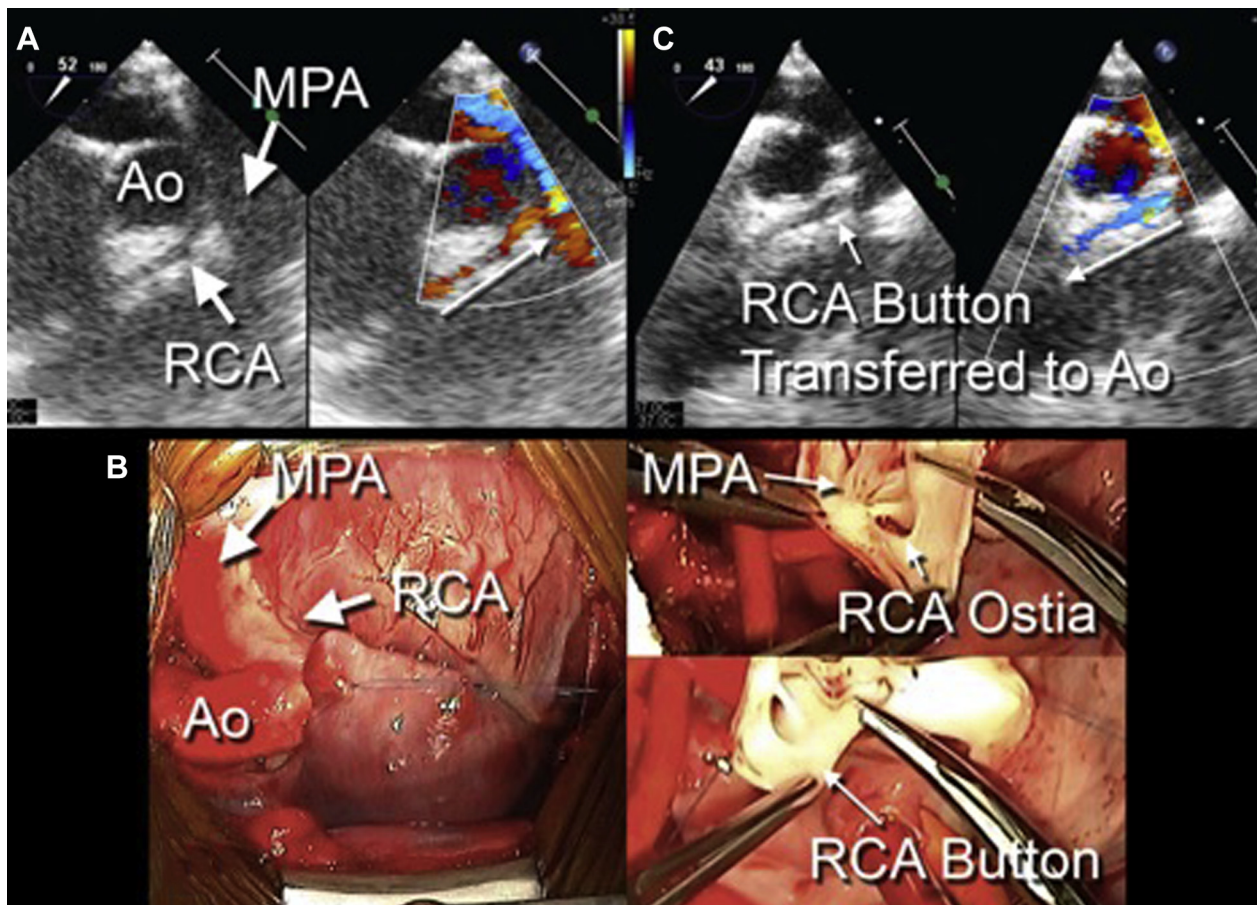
Preoperative transthoracic echocardiogram shows flow reversal in the right coronary artery (RCA), concerning for anomalous right coronary artery off the pulmonary artery (A). Intraoperative findings are displayed (B), along with postoperative transthoracic echocardiography showing normal flow directionality visualized in the RCA after reimplantation (C). Ao, Aorta; MPA, main pulmonary artery.
